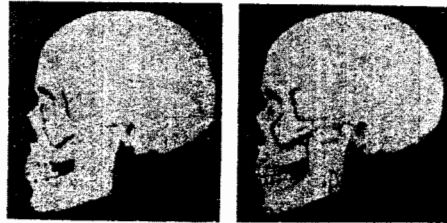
Preoperative radiographs of ankylosed left mandibular joint.
